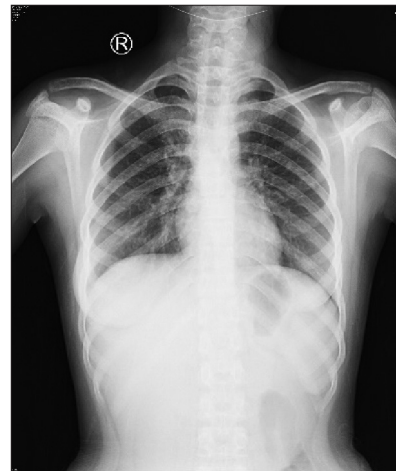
PA view of chest X-ray showing no significant abnormality
